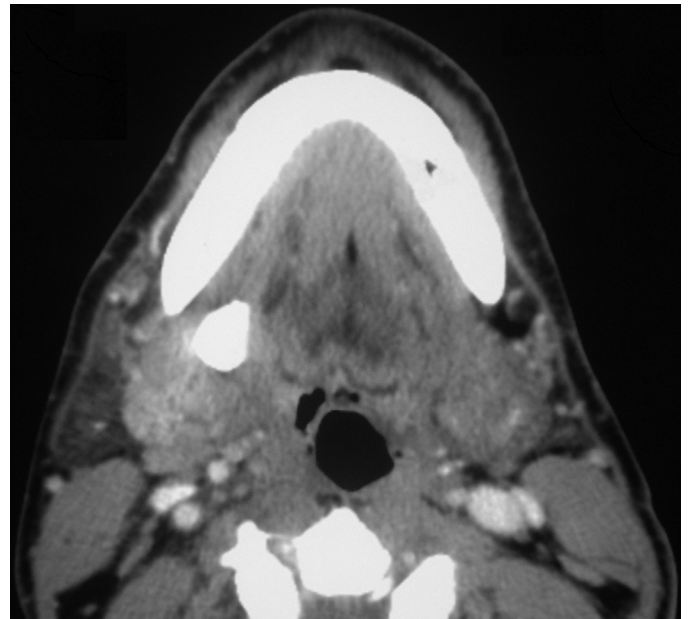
Submandibular salivary gland stone greater than 5 mm (megalith displayed in computed tomography).
